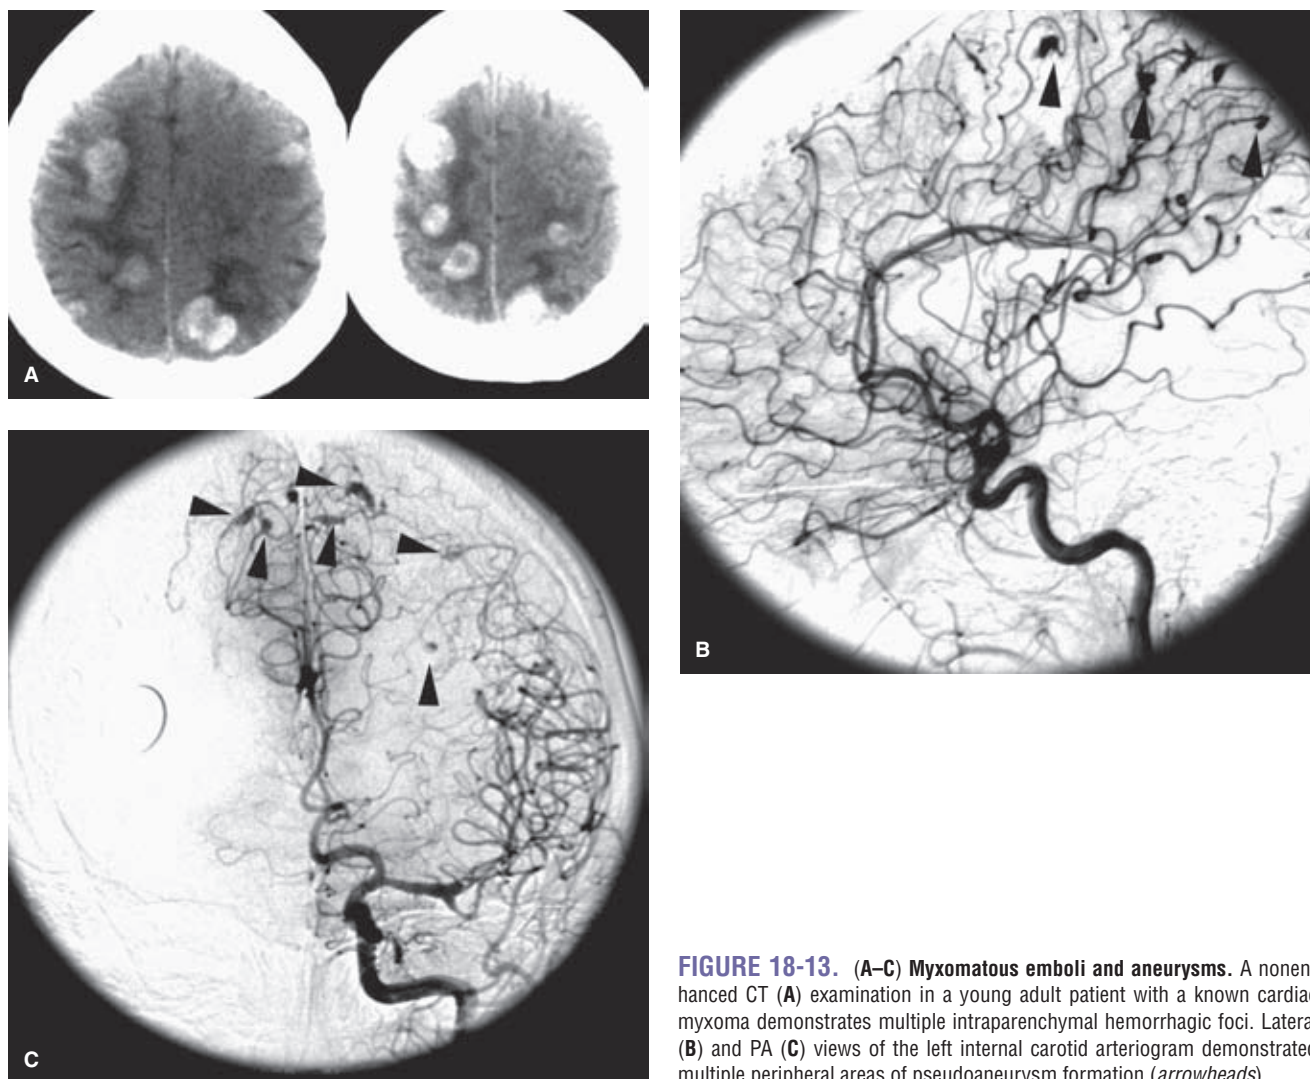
(A–C) Myxomatous emboli and aneurysms. A non-enhanced CT (A) examination in a young adult patient with a known cardiac myxoma demonstrates multiple intraparenchymal hemorrhagic foci. Lateral (B) and PA (C) views of the left internal carotid arteriogram demonstrated multiple peripheral areas of pseudoaneurysm formation (*arrowheads*).
